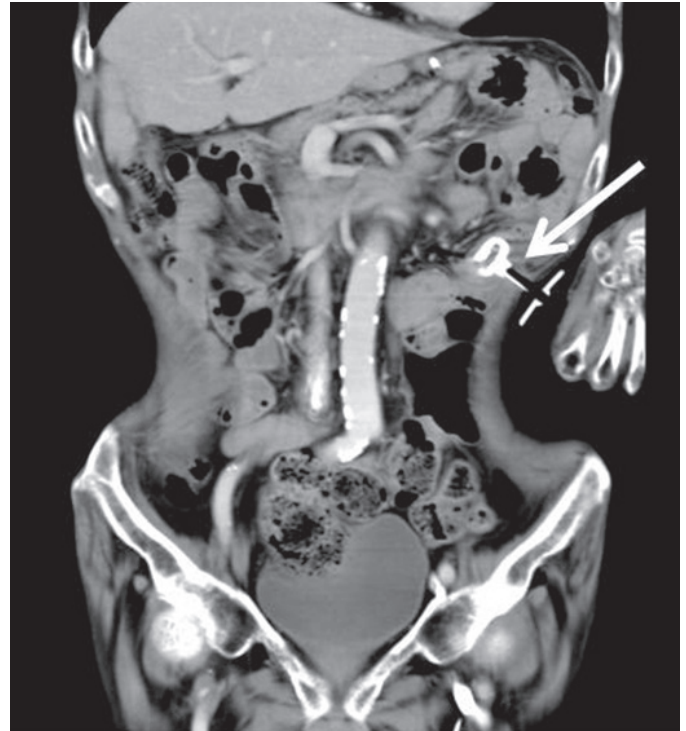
CT scan after replacement of jejunal tube to EndoVive Bumper G tube (arrow).
